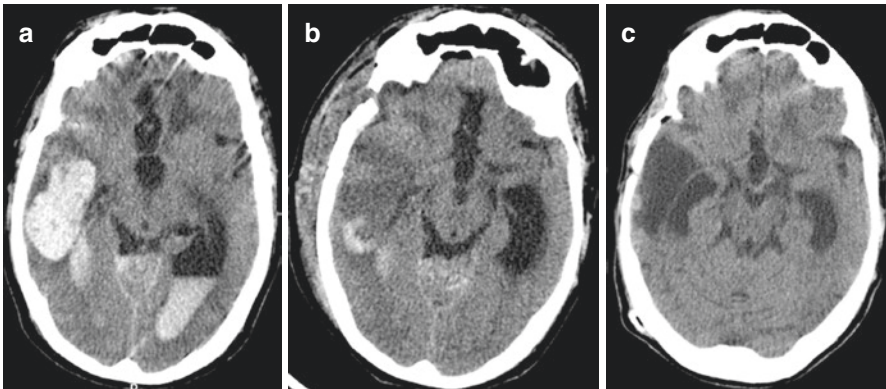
Spontaneous right temporal ICH with intraventricular extension (a), in a 50-year-old male. He was taking warfarin, INR 2.21 for a deep venous thrombosis (DVT) 4 months earlier. Angio-CT did not disclose any vascular lesions. Due to its superficial topography, it was decided to drain the hematoma with a craniotomy and placement of an EVD (b). 13 months after the event, with a shunt procedure for hydrocephalus having been carried out, the patient presented with an mRankin of 3, with some degree of dependence, mainly because of cognitive dysfunction. (Case from author’s departmental archive)
